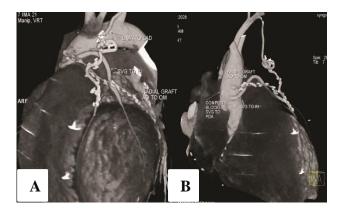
Reconstructed CT images (A) and (B): Two different views showing patent LIMA-LAD, SVG-RI and radial-OM grafts; blocked SVG graft from aorta to PDA.
